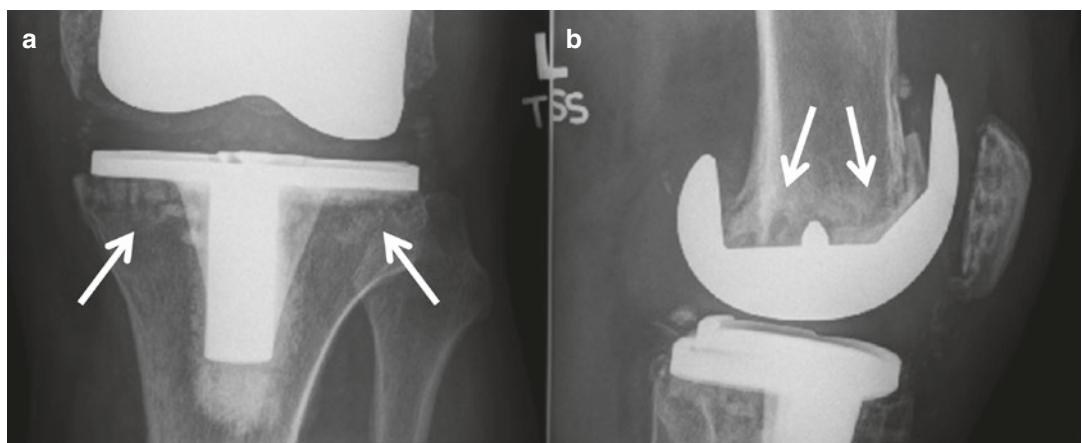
Fluoroscopically controlled close-up radiographic views of the implant interfaces showing more clearly the tibial side osteolysis (a, arrows) and femoral radiolucencies (b, arrows)
